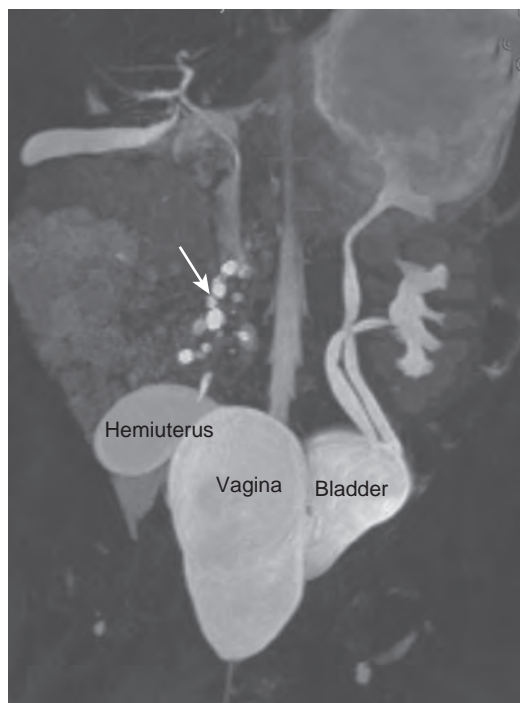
Use of magnetic resonance imaging to define the complex anatomy of a child with an ectopic ureter associated with a right dysplastic, cystic kidney (arrow) draining into an obstructed hemivagina and producing urinary dilation of the right hemiuterus. Initial therapy constituted creating a distal window between the two vaginae. Subsequently she underwent right nephrectomy.
